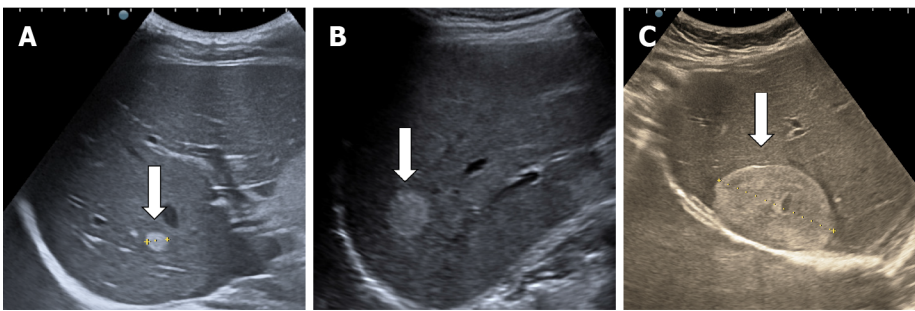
Typical hepatic hemangioma. Ultrasonography shows the hemangioma as a hyperechoic mass with sharp margins. A and B: Small hepatic hemangioma; C: Large hepatic hemangioma.
